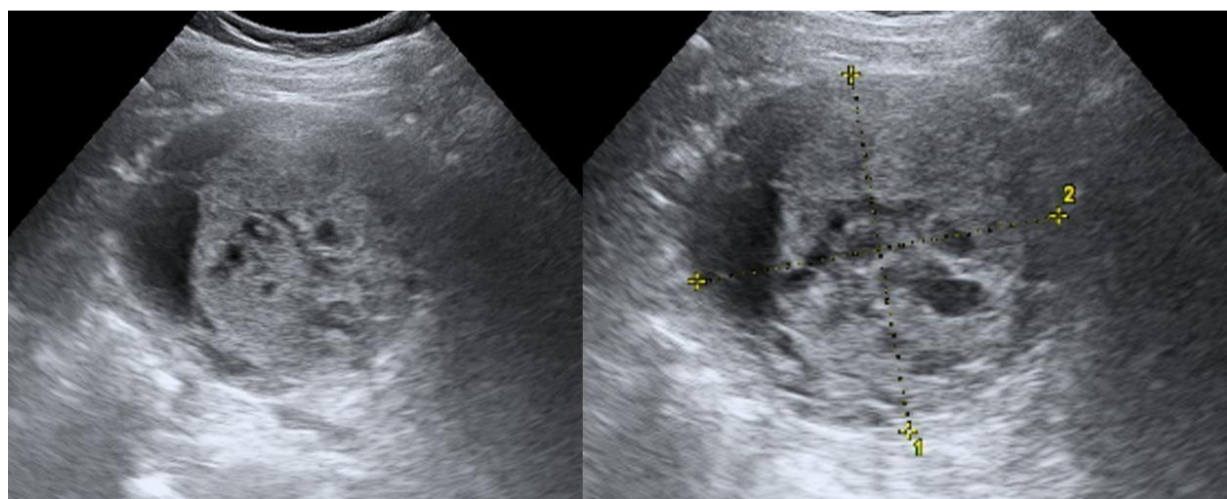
Abdominal ultrasound images demonstrating a well-circumscribed, encapsulated mass in the region of the pancreatic tail, with heterogeneous mixed solid and cystic content.
